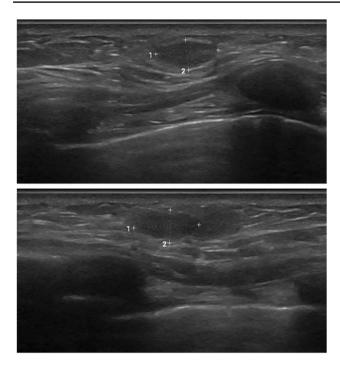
Sonographic examination of the right breast
